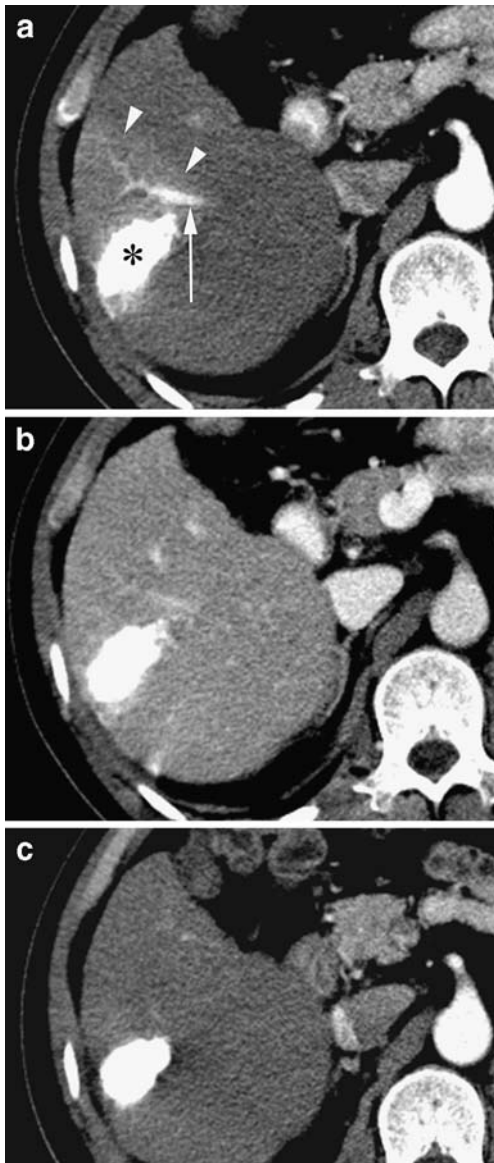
A 66-year-old man who had undertaken selective TACE for a single hepatocellular carcinoma showing a THAD related to arterioportal fistula formation on follow-up CT. a Transverse contrast-enhanced hepatic arterial phase dynamic CT images obtained 4 weeks after TACE shows an early filling of contrast material in the peripheral portal vein branch (arrow) and surrounding subcapsular, wedge-shaped increased attenuation (arrowheads) adjacent to the area of iodized-oil accumulation (asterisk). b Portal phase dynamic CT shows no abnormal attenuation density at the corresponding area of arterial hypervascularity. c Three-month follow-up arterial phase dynamic CT shows disappearance of arterioportal fistula and THAD without gross parenchymal change
